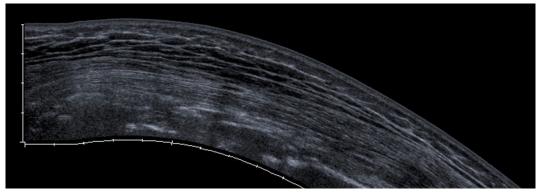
Ultrasonographic spread of proximal femur prior to percutaneous biopsy
